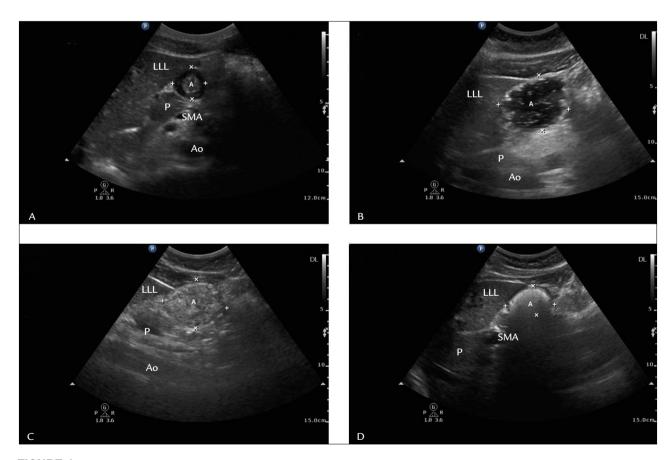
A. Ultrasonography image of the gastric antrum with an empty stomach. The antrum appears small and empty, with a "bull's eye" appearance. B. Ultrasonography image of the gastric antrum after ingestion of a clear fluid. Note that the antrum appears distended with hypoechoic or anechoic content. Small gas bubbles giving the appearance of a "starry night." C. Ultrasonography image of the gastric antrum after ingestion of milk. The antrum appears round and distended. There is increased echogenicity, with an image that resembles coagulated content. D. Ultrasonography image of the gastric antrum 10 minutes after ingestion of solid food (a sandwich). Image that resembles "frosted glass."
